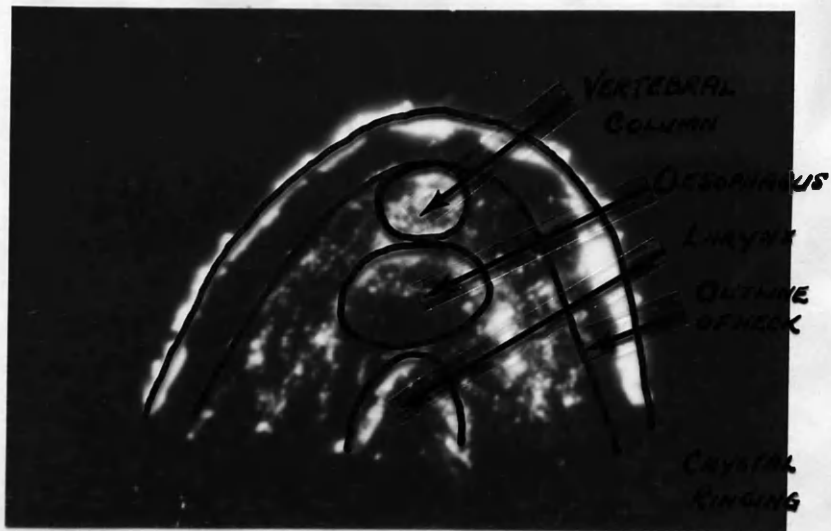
SCAN OF POSTERIOR ASPECT OF NECK.
